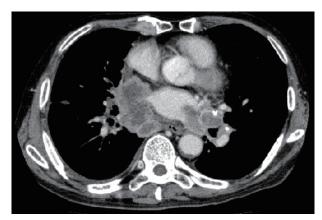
Chest computed tomography showing a large mass in the right middle lobe of the lung.
